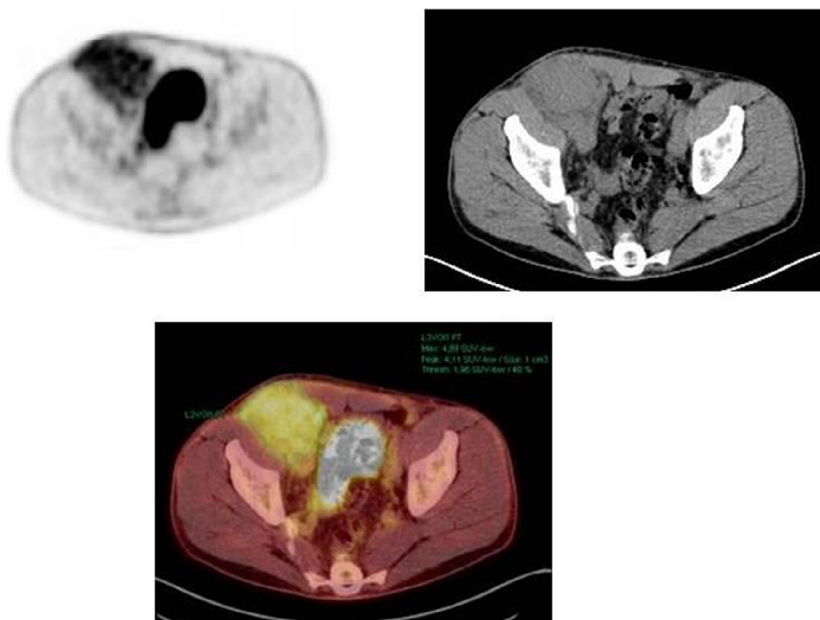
Extramedullary plasmacytoma arising along the scar of a previous surgery (positron emission tomography/computed tomography). With permission from the *Archives of Clinical and Biomedical Research*.
